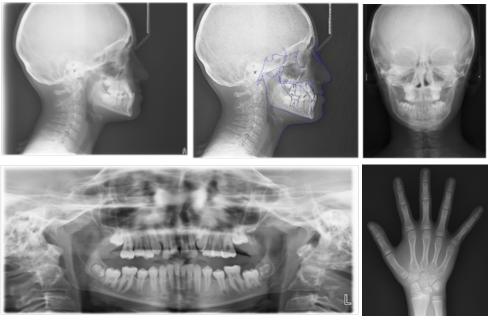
Pretreatment Radiographic Figures
